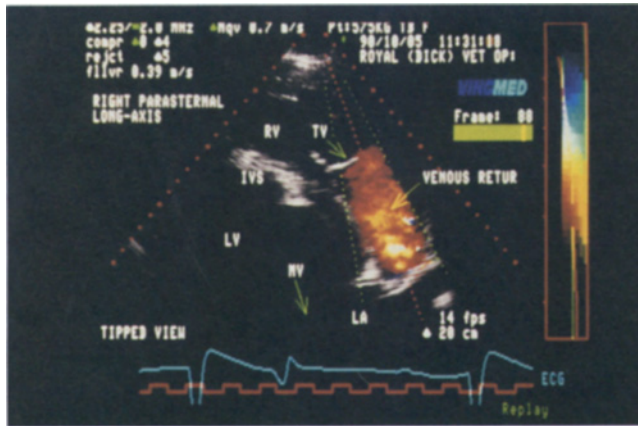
Colour flow Doppler study from a right parasternal long-axis view showing a red flow signal in the right atrium during the second part of systole. The lighter shades of red represent areas of high velocity flow.
